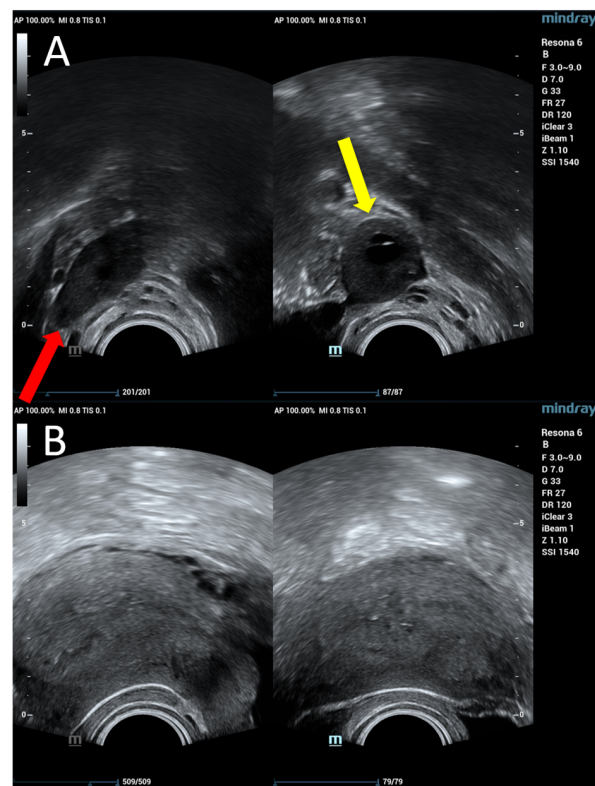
Transvaginal ultrasound systematically excluding tubal ectopic pregnancy, showing (A) normal right adnexa (red arrow) and left adnexa (yellow arrow) with no evidence of extraovarian masses or tubal distension, and (B) empty uterine cavity with normal endometrial stripe thickness, confirming absence of intrauterine pregnancy. The systematic evaluation of both adnexal regions is crucial for differential diagnosis, as tubal ectopic pregnancy represents the most common form of extrauterine pregnancy.
